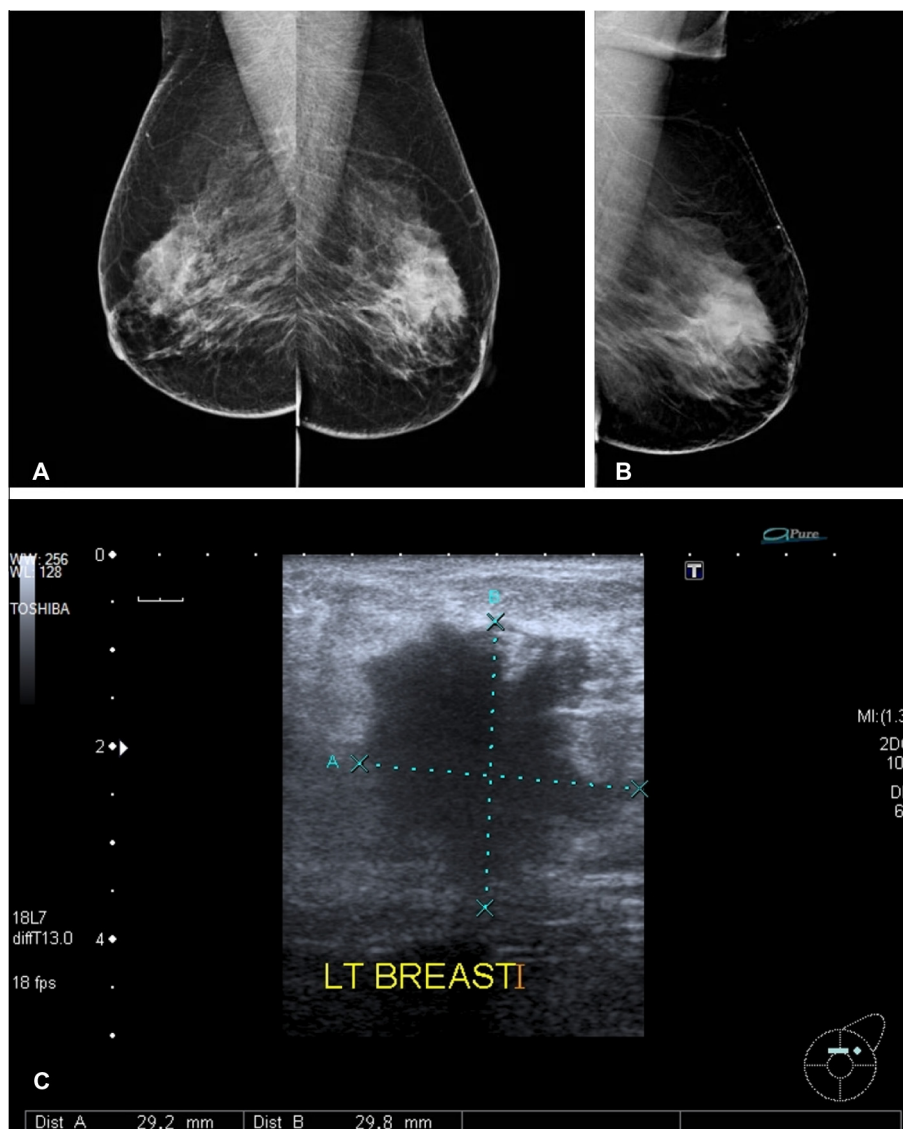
Left breast large invasive duct carcinoma that is hardly seen on the FFDM images (A). It was assigned as BIRADS 4. The carcinoma appears more evident on the tomosynthesis slice (B) and was upgraded to BIRADS 5. Complementary ultrasound (C) confirmed the tomosynthesis findings.
